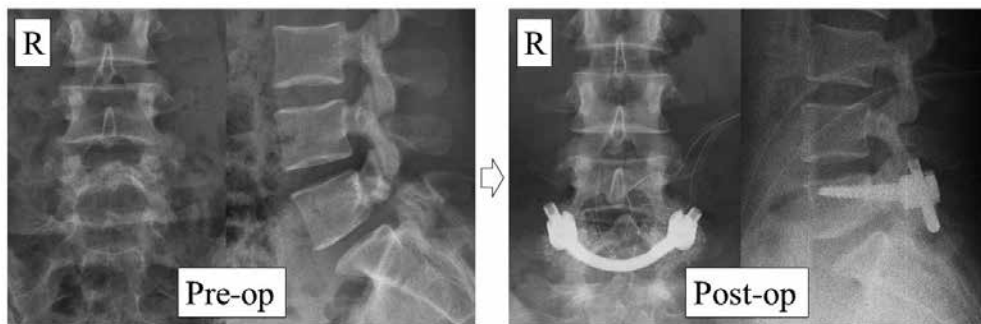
Pre-op and post-op X-rays
